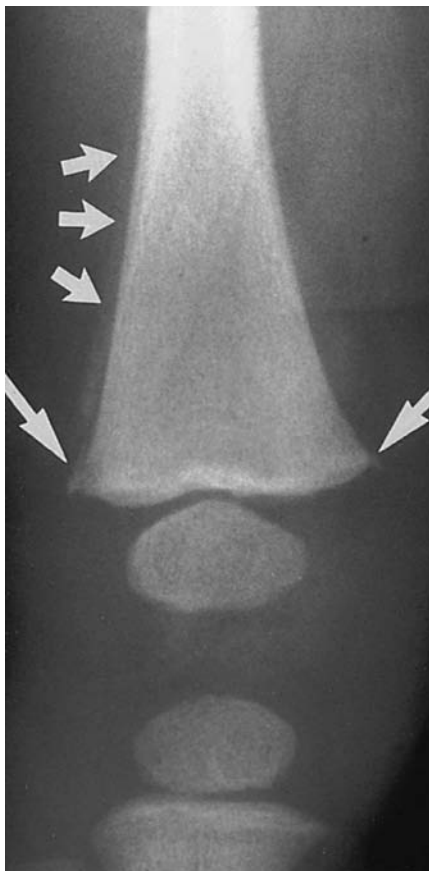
Radiograph of the right knee of a 3.5-month-old victim of child abuse. The metaphyseal corner fractures (*large arrows*) are considered diagnostic of abuse. Also evident is periosteal new bone formation (*small arrows*), proof of a significant delay between injury and medical evaluation.
